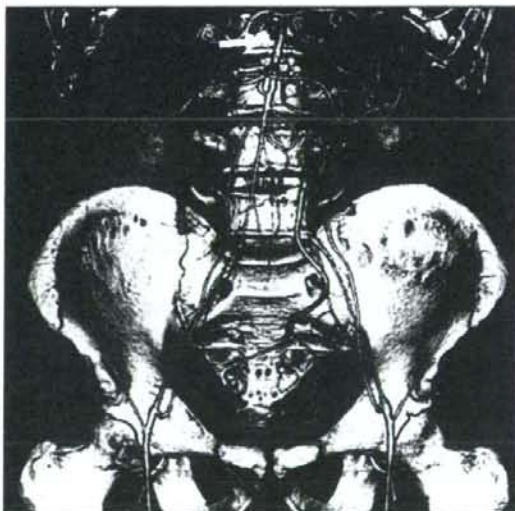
Computed tomography angiography at follow-up, showing completely obstructed infrarenal aorta (arrow) and bilateral common iliac arteries
